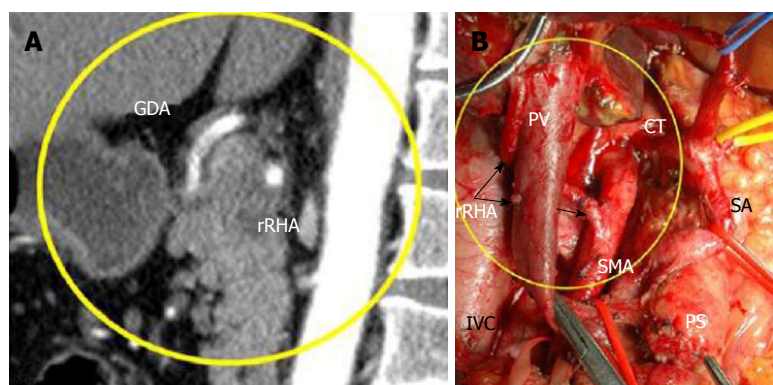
In 75-year-old woman (case 1), 360° PDAC encasement of the replaced right hepatic artery was diagnosed on computed tomography (A), while endoUS data described only tumor abutment with the artery. Arterial phase, Sagittal images: CT showed circumferential infiltration of the rRHA, B: Intraoperative photograph. An extended Whipple procedure was performed. There were no signs of rRHA or SMA involvement during surgery (arrows). The level of resection was R1 because of the contact of the rRHA with the tumor. SMA: Superior mesenteric artery; rRHA: Replaced right hepatic; LHA: Left hepatic; RGEA: Right gastro-epiploic arteries; CT: Celiac trunk; SMV: Superior mesenteric; PV: Portal; LRV: Left renal vein; T: Tumor; PS: Pancreatic stump.
